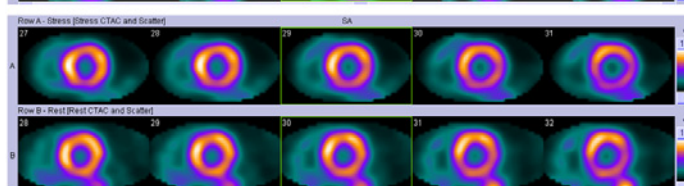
The resulting image from FBP and Flash 3D reconstruction. Top row shows the alignment of cardiac data matching CT and SPECT images. Middle row shows midventricular short-axis slices reconstructed with FBP. Note the presence of an inferior wall perfusion defect on stress-rest images indicating an inferior wall myocardial infarction. Bottom row shows midventricular short axis slices reconstructed with Flash 3D. Note the absence of the inferior wall defect, suggesting that this was an artifact. Also, better contrast between the left ventricular walls and cavity and better visualization of the right ventricle.
